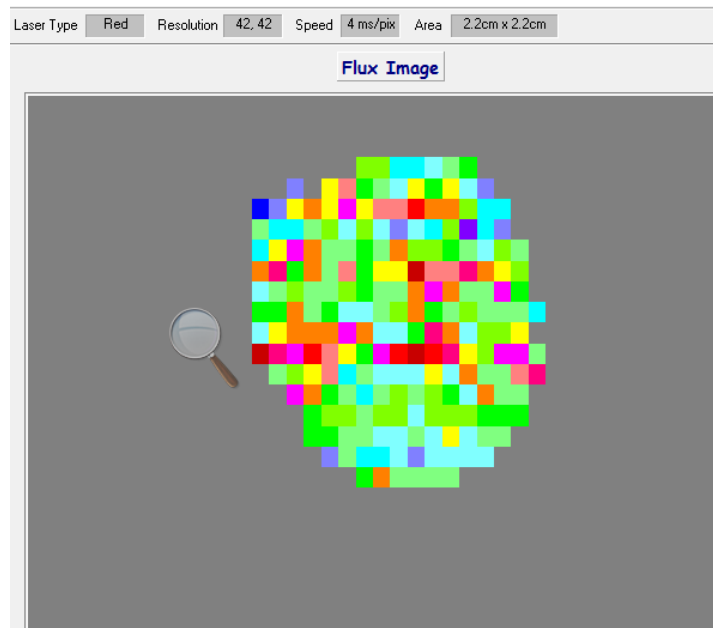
2D perfusion image generated using laser Doppler perfusion imaging. Brighter colours indicate greater flux.
